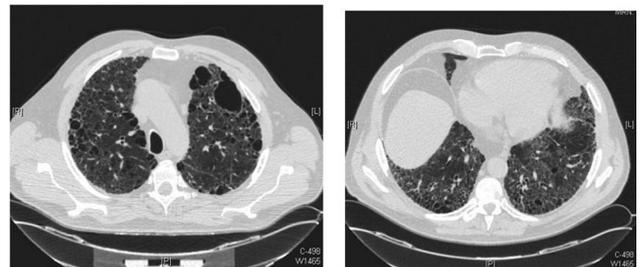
High-resolution computed tomogram of patient 2, in February 2009, shows a reticular infiltrative process, architectural distortion, peripheral honeycombing, and traction bronchiectasis.
